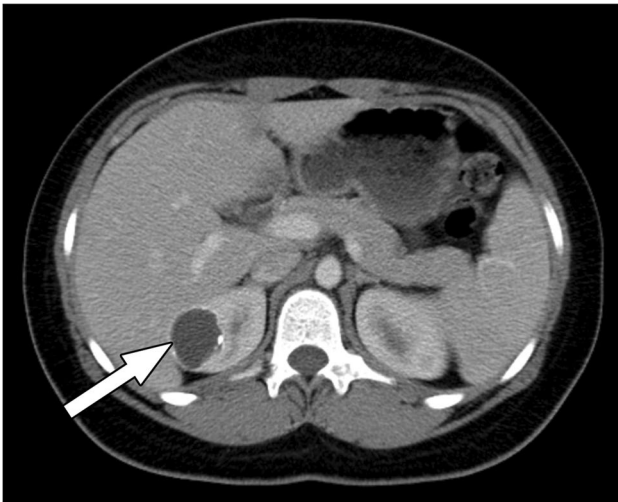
14-year-old girl with remote disseminated histoplasmosis and kidney involvement. Axial abdominal CT image with IV contrast material shows a low attenuation, cystic lesion with a thin rim of calcifications in the upper pole of the right kidney (arrow). Additional images from the same CT (not shown) demonstrated splenic calcifications and a calcified nodule in the imaged right lung lower lobe typical of histoplasmosis
